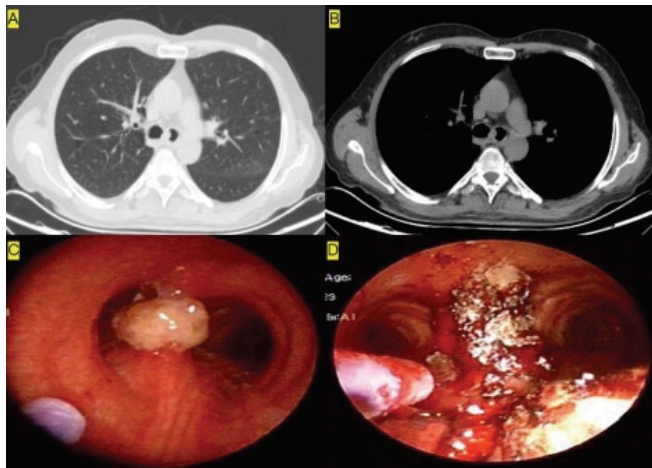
CT bronchoscopy and images of a tumor localized in the carina. A: Parenchymal section CT image of the tumor in the carina localization, B: Mediastinal section, C: FOB image of the tumor D: FOB image after endobronchial treatment.
